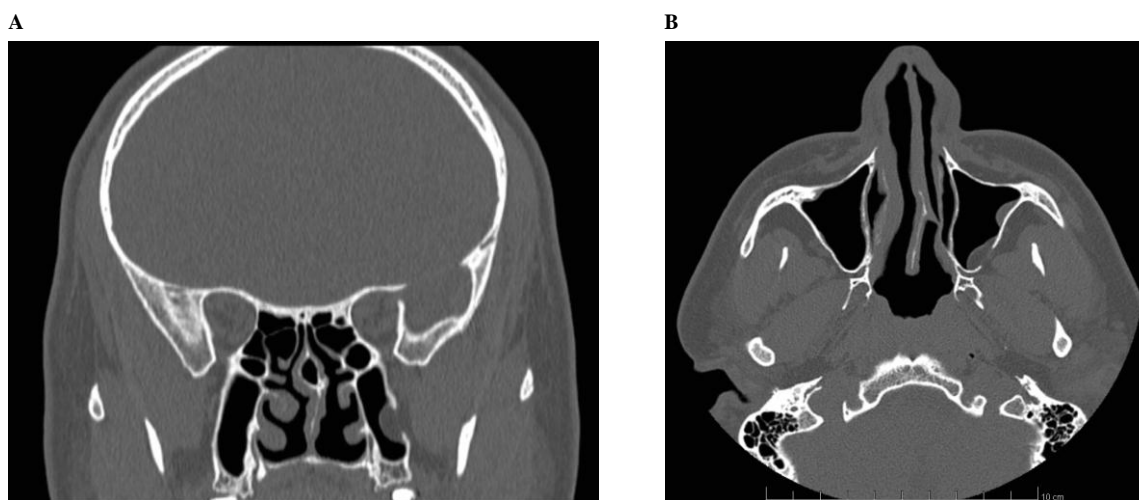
Computed tomography image of paranasal sinuses (post-inflammatory changes).
